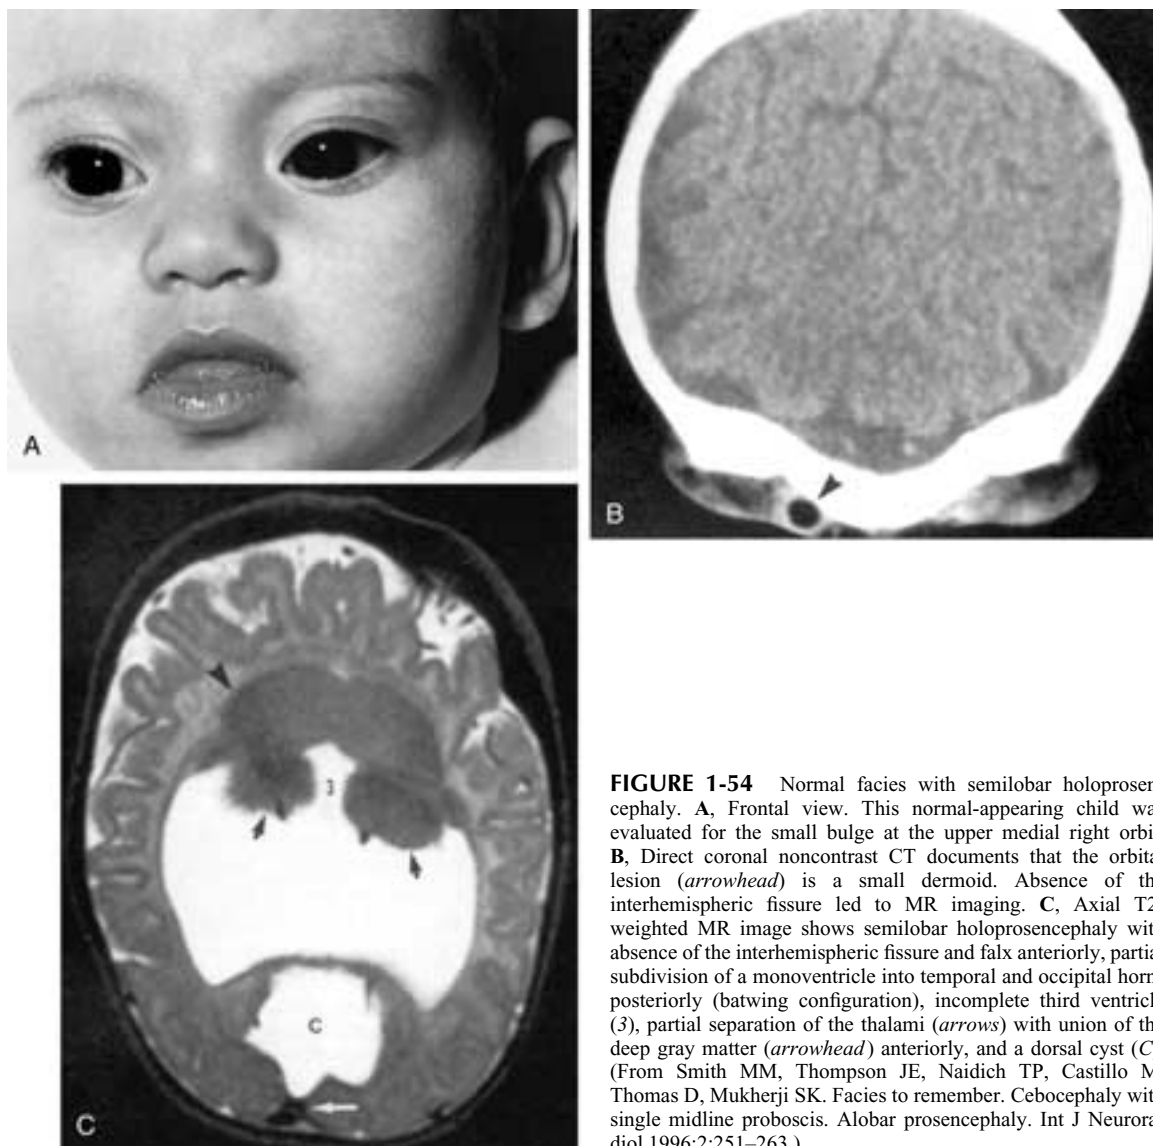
Normal facies with semilobar holoprosencephaly. A, Frontal view. This normal-appearing child was evaluated for the small bulge at the upper medial right orbit. B, Direct coronal noncontrast CT documents that the orbital lesion (arrowhead) is a small dermoid. Absence of the interhemispheric fissure led to MR imaging. C, Axial T2-weighted MR image shows semilobar holoprosencephaly with absence of the interhemispheric fissure and falx anteriorly, partial subdivision of a monoventricle into temporal and occipital horns posteriorly (batwing configuration), incomplete third ventricle (3), partial separation of the thalami (arrows) with union of the deep gray matter (arrowhead) anteriorly, and a dorsal cyst (C). (From Smith MM, Thompson JE, Naidich TP, Castillo M, Thomas D, Mukherji SK. Facies to remember. Cebocephaly with single midline proboscis. Alobar prosencephaly. *Int J Neuroradiol* 1996;2:251–263.)
